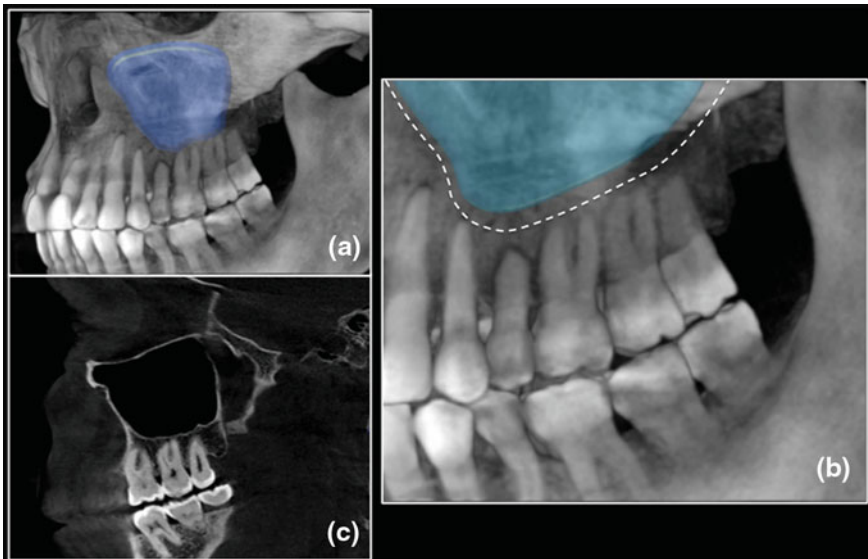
Left maxillary sinus. a* sinus representation on a CBCT-3D reconstruction of the skull; *b* anatomical detail of the relationship between the inferior sinus wall and the superior dental roots; *c* corresponding CBCT-2D sagittal image passing through the left maxillary sinus
